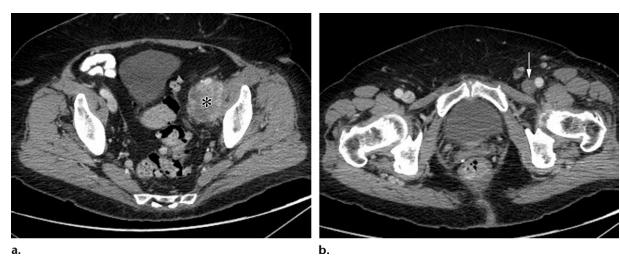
Retroperitoneal leiomyosarcoma with bland thrombus in a 76-year-old woman who presented to the emergency department with left leg pain and swelling. (a) Axial contrast-enhanced CT image of the pelvis shows an enhancing mass along the left pelvic sidewall (*), in the region of the left external iliac vein, diagnosed as leiomyosarcoma. (b) Axial contrast-enhanced CT image obtained inferior to a shows a bland thrombus in the left common femoral vein (arrow).
